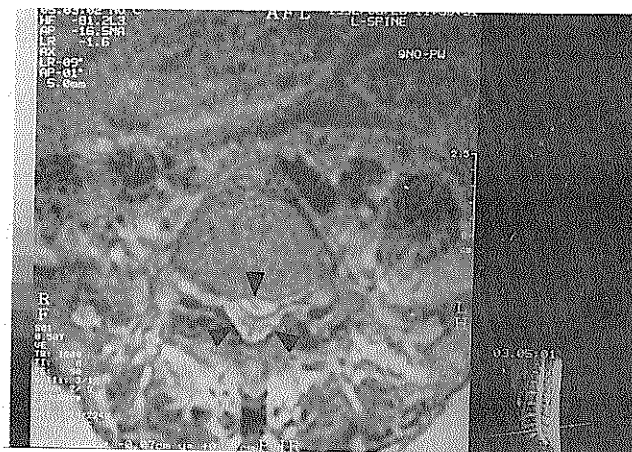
Axial scan, T2-weighted image. The mass has high intensity signal and encircles the dural sac (arrows).
